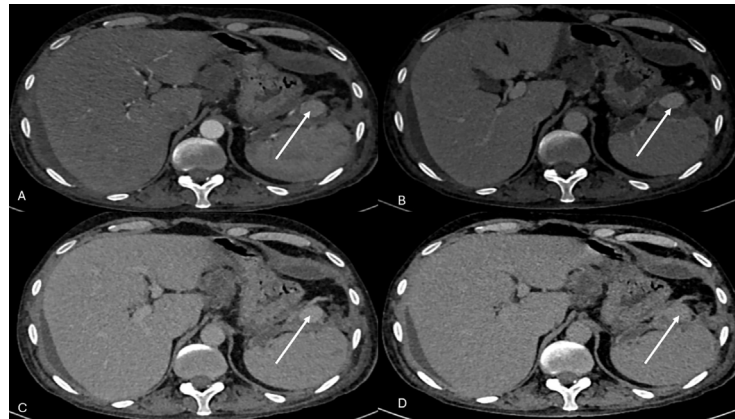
Case 2. CT scan of the abdomen. Axial Contrast enhanced CT scan of the abdomen at the level of the splenic hilum with arterial phase (A), portal phase (B), venous phase (C) and delayed [5 minutes postcontrast] phase. A well-defined pseudoaneurysm is noted in the distal splenic artery adjacent to the splenic hilum with progressive filling of contrast (white arrow in A,B and C) and persistence of contrast in delayed phase (white arrow in D).
